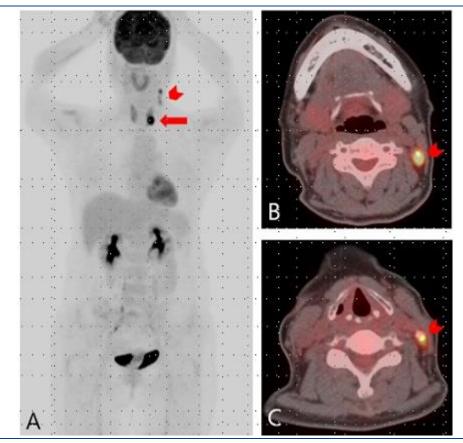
A 55-year-old woman with a 0.9 cm papillary thyroid carcinoma in her left thyroid gland. Maximal-intensity-projection image (A) and transaxial image (B, C) showed a few focal areas of $2-[^{18}F]FDG$ uptake in left thyroid lobe (arrow in A, SUVmax = 15.9), left cervical level II(arrowhead in B, SUVmax = 7.3) and III(arrowhead in C, SUVmax = 3.8). All lymph nodes that showed abnormal findings on $2-[^{18}F]FDG$ -PET/CT were proven to be metastatic at surgery
